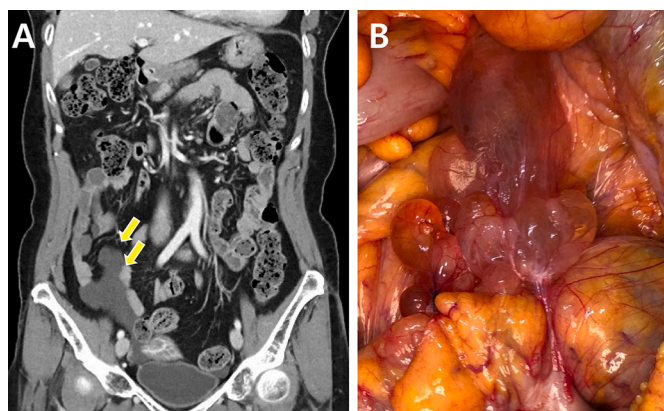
Perioperative images of peritoneal benign cystic mesothelioma; A. preoperative computed tomography image (arrow, PBCM lesions), B. the intraoperative image.
